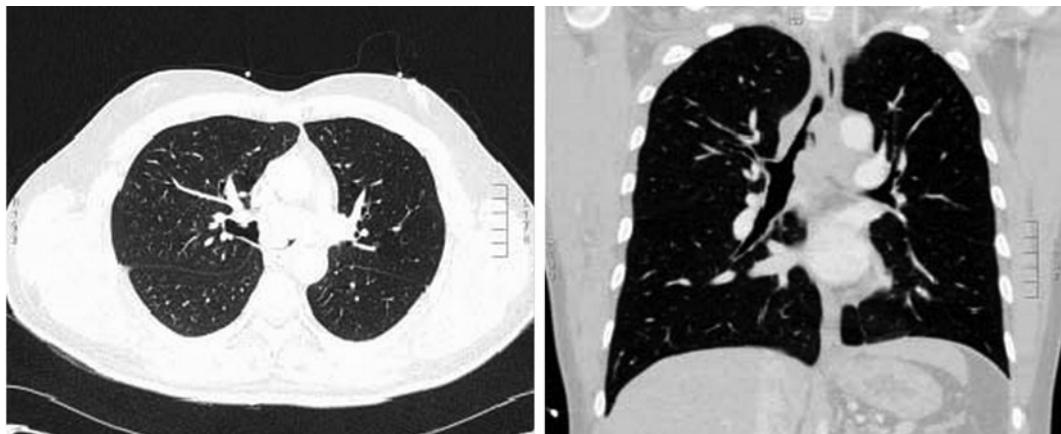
CT demonstrating severe intrinsic central airway obstruction involving the tracheal carina and left main bronchus.
